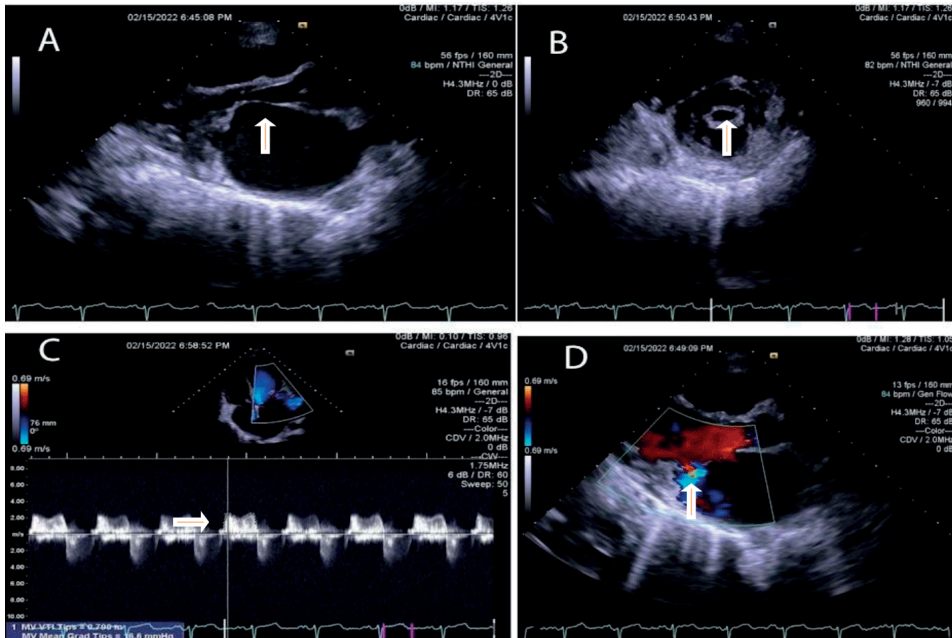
Echocardiographic frames from a 16 years old girl demonstrating hockey stick appearance of the anterior leaflet of mitral valve with enlarged left atrium (A, arrow), severe mitral stenosis (valve area 0.75cm^2) by planimetry (B, arrow) and by the trans-mitral valve pressure gradient (18mmHg) (C, arrow). Panel D shows the associated trivial mitral regurgitation.
